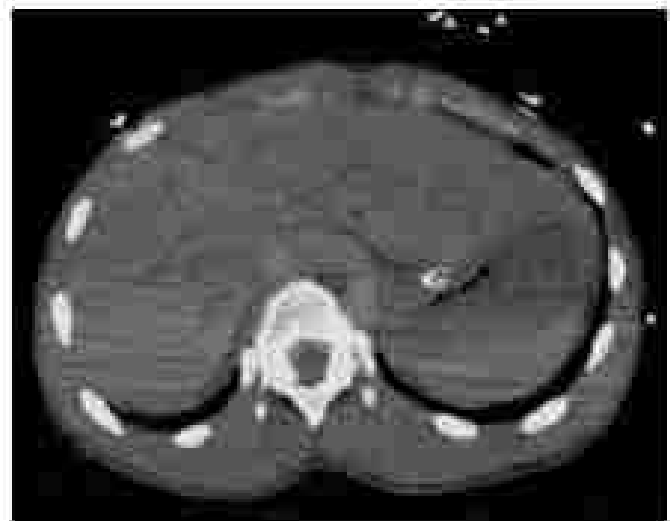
Abdominal computed tomography in a patient with grade 4 blunt cardiac injury demonstrated significant hepatomegaly and edema around the liver.
